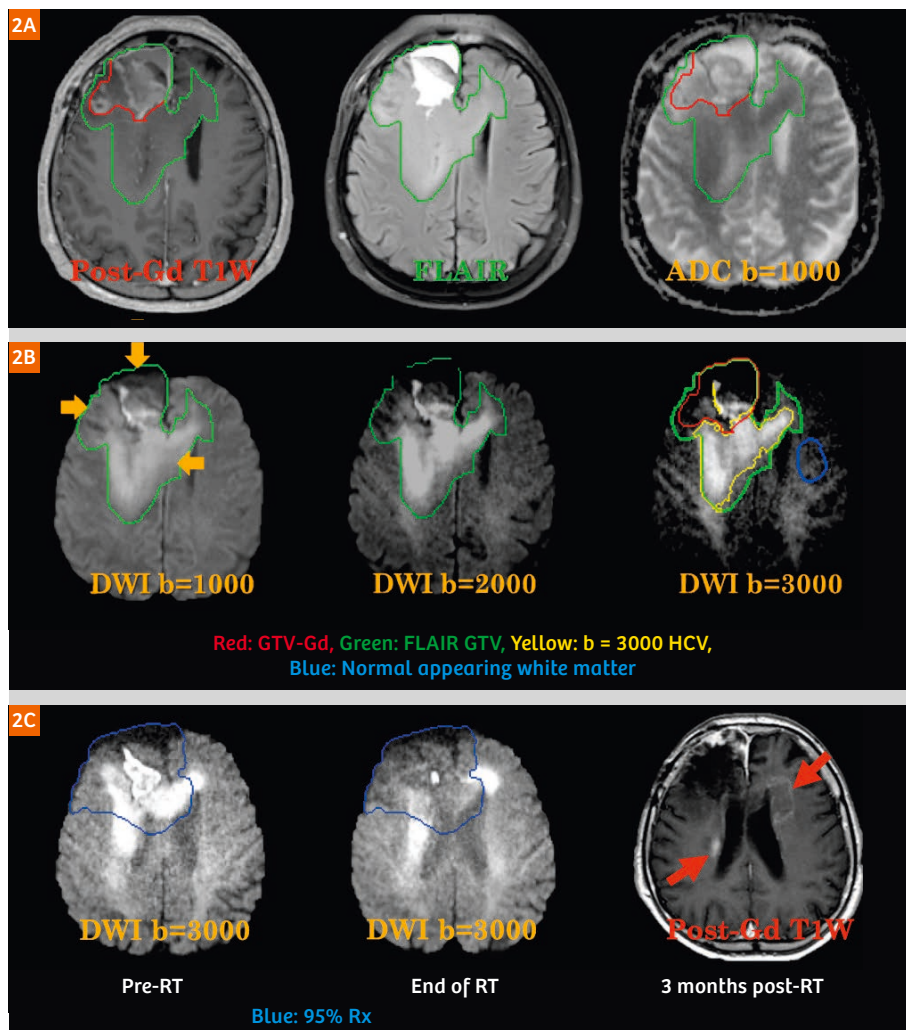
High b-value DWI for detection of hyper-cellularity in patients with non-contrast enhanced sub-volume of glioblastoma. (2A) There was no difference in depicting tumor volume between post-Gd T1 (red contour, also used as the gross target volume for RT) and conventional ADC maps acquired with a b-value of 1000 s/mm².
